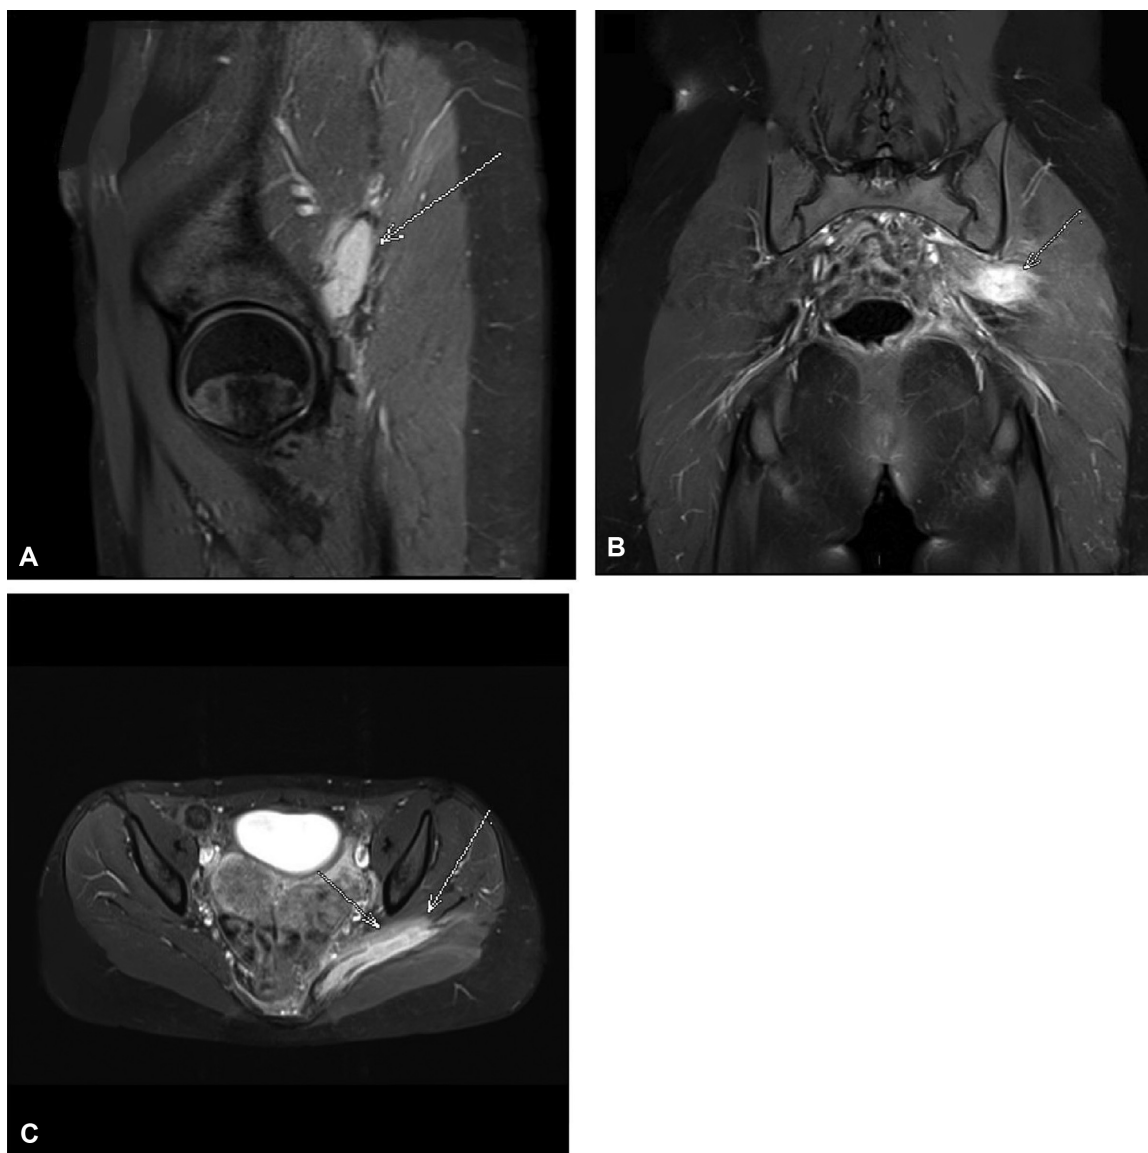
Magnetic resonance imaging showing increased signaling in the left piriformis muscle associated with the presence of fluid collection. (A) Sagittal plane weighted proton density with fat suppression signal. (B) Coronal T1-weighted fat-suppressed signal after gadolinium contrast. (C) Axial T1-weighted fat-suppressed signal after contrast with gadolinium.
